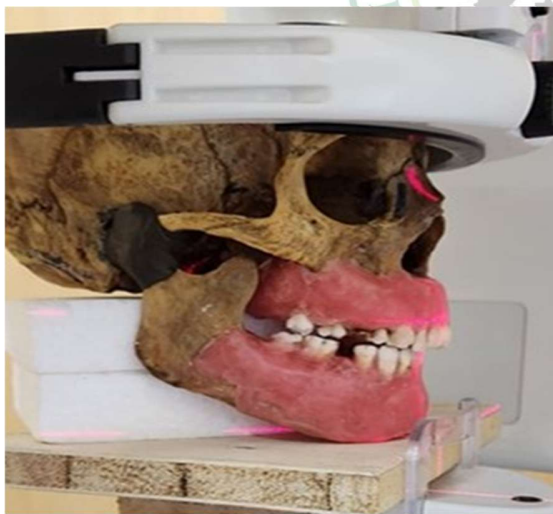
Positioning of skull and mandible assembly during CBCT scanning.
